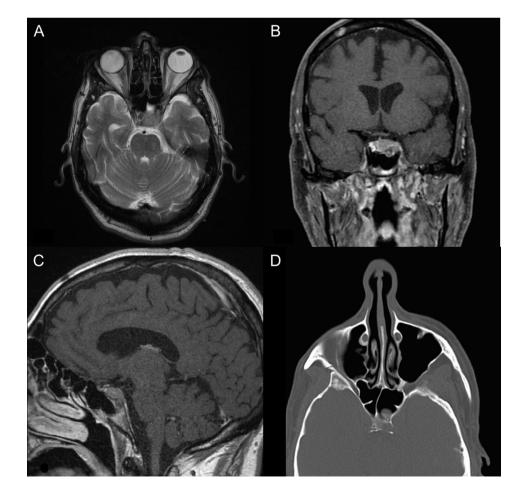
Pre-operative images of sellar tumor (A) Axial T2-weighted MRI (B) Sagittal T1-weighted post-contrast MRI (C) Coronal T1-weights post-contrast MRI (D) CT of the sinuses demonstrating cavernous invasion.
